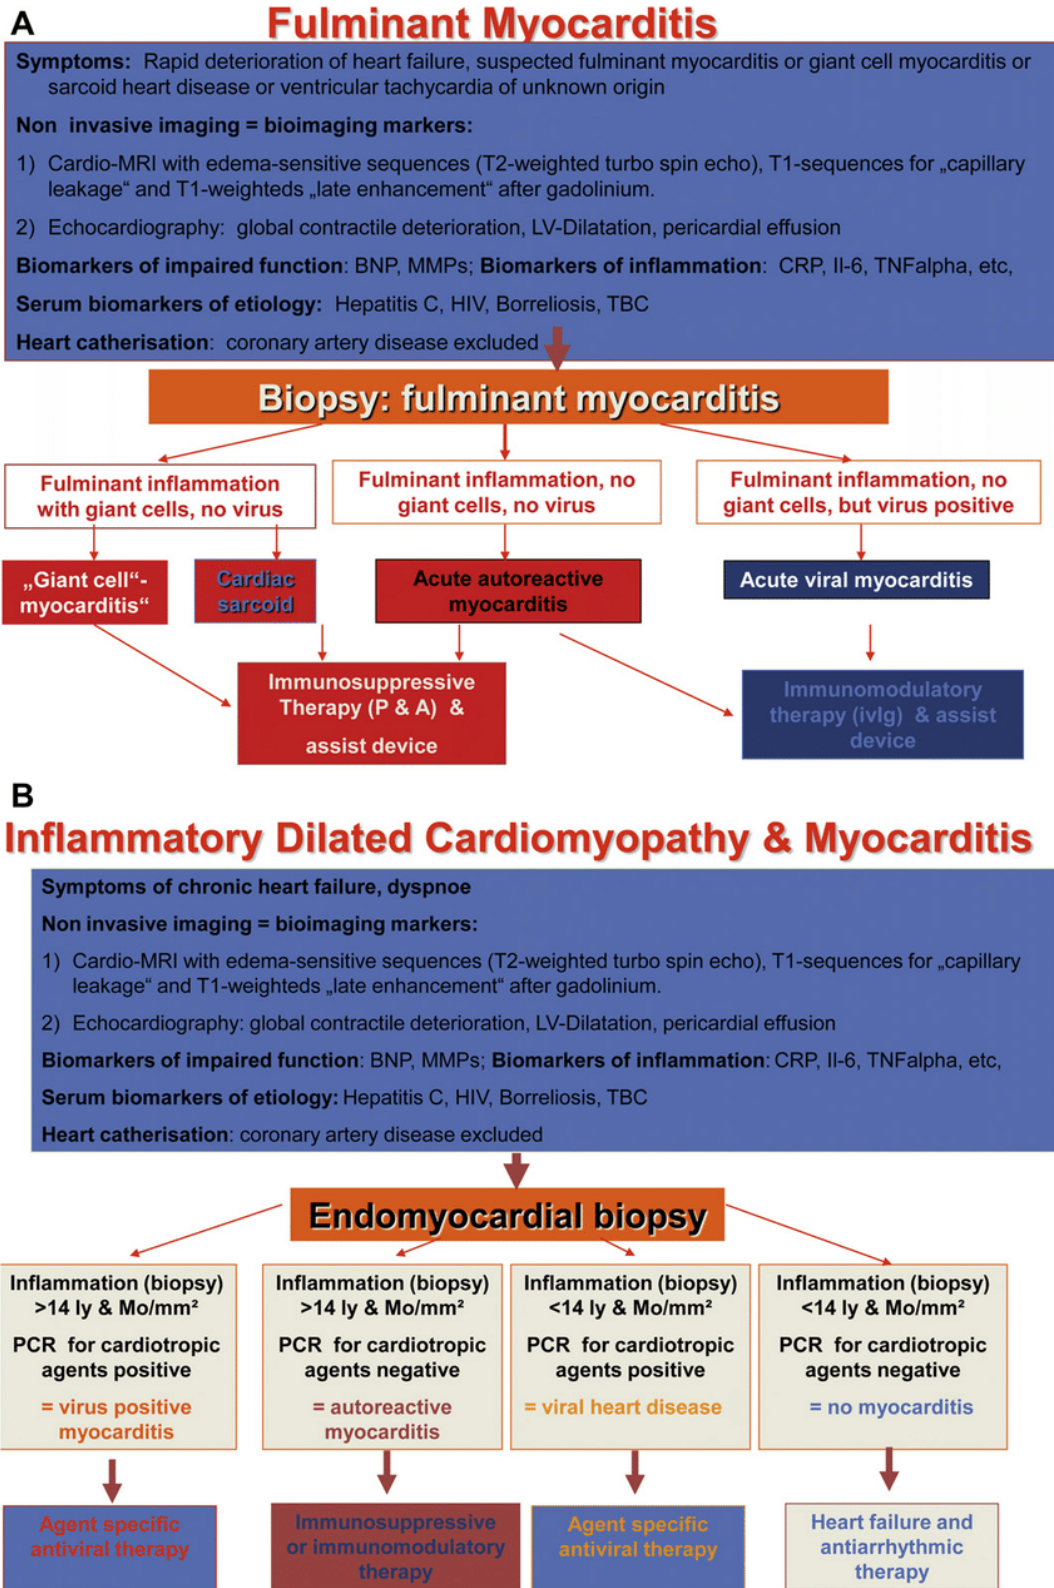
Stepwise diagnostic pathway for myocarditis using clinical suspicion, echocardiography, biomarkers, CMR, and endomyocardial biopsy when indicated [22].
